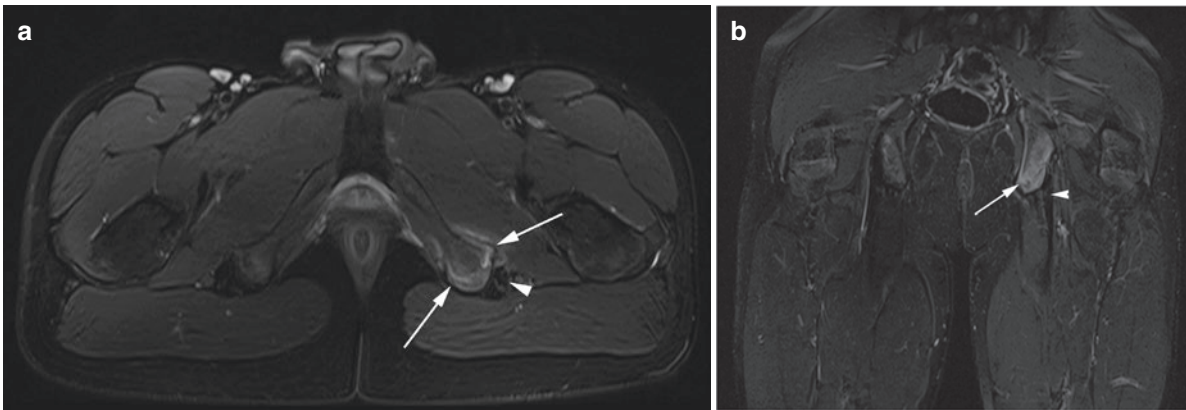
Apophyseal injury. A 17-year-old soccer player with subacute hamstring pain. (a) Axial and (b) coronal T2FS MR images show left ischial apophysis edema, stress fracture and periosteal reaction (arrow), and normal hamstring tendons (arrowheads)
